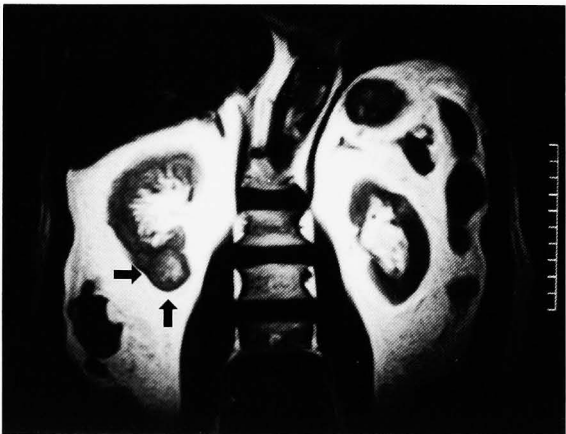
Abdominal MRI revealed a heterogeneous lower pole mass (arrow) at the right kidney (T2 weighted).
